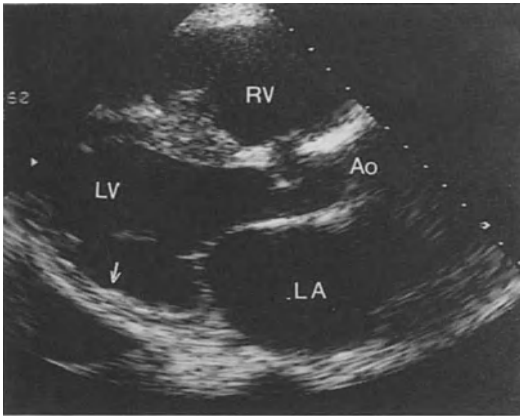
Two-dimensional echocardiogram showing inferior myocardial infarction and left atrial enlargement.
